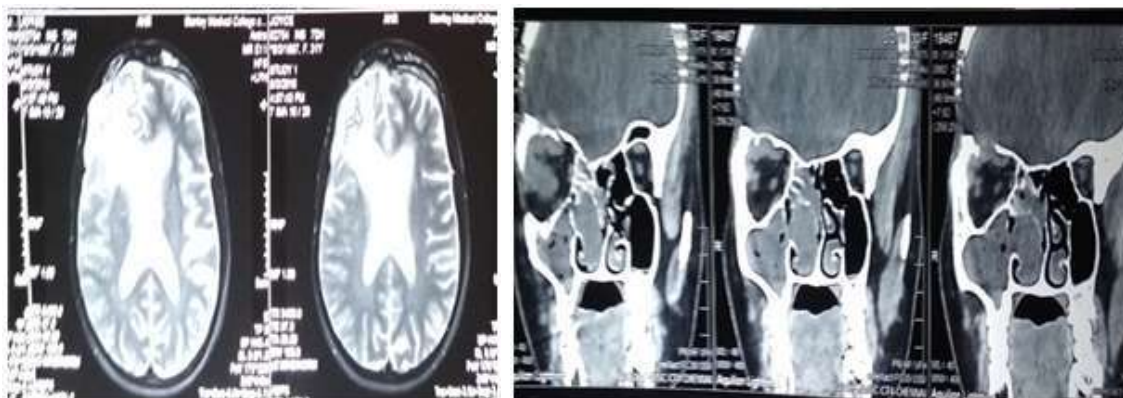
MRI and CT PNS 2 yrs. Post surgery
